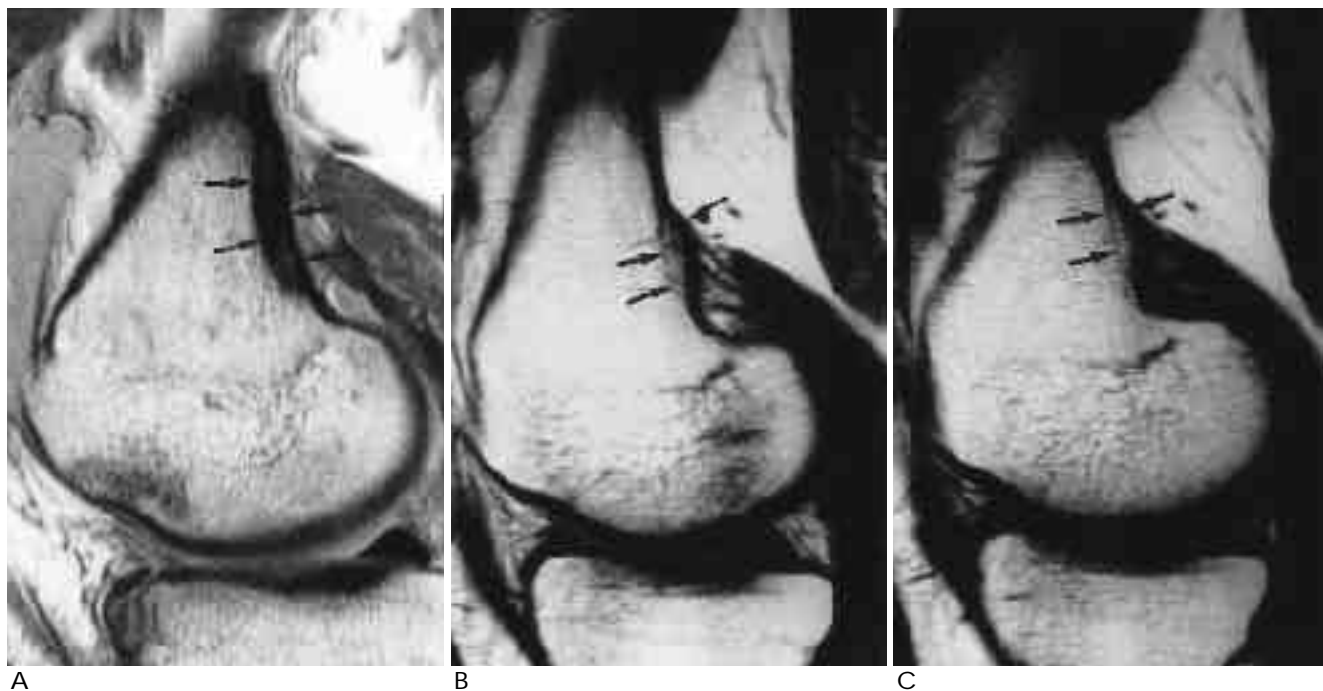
Proton density-weighted sagittal MR images.
